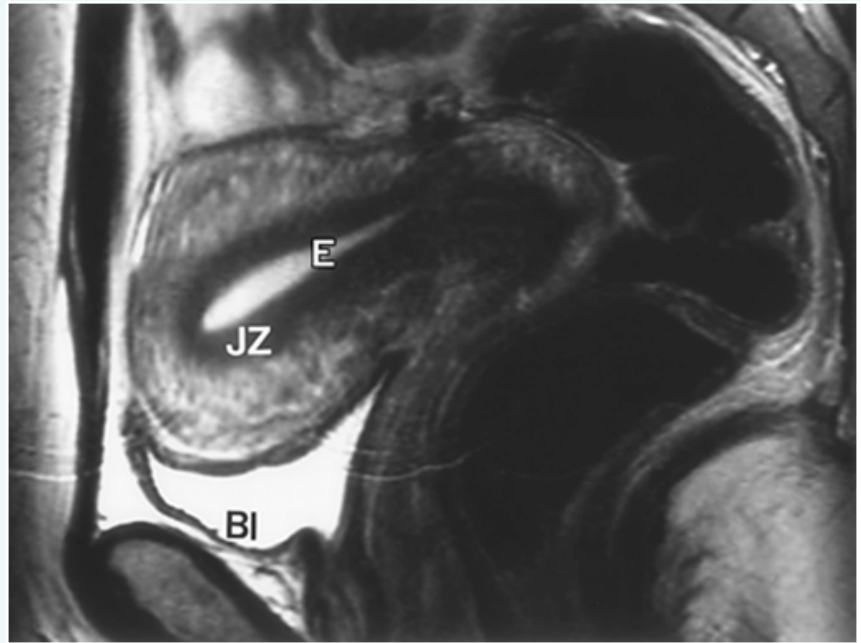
normal MRI appearance of the endometrium and myometrium. The junctional zone (JZ) is the inner layer of the myometrium seen as a low signal band on T2 weighted images. From RadioGraphics, 19, S147-S160
